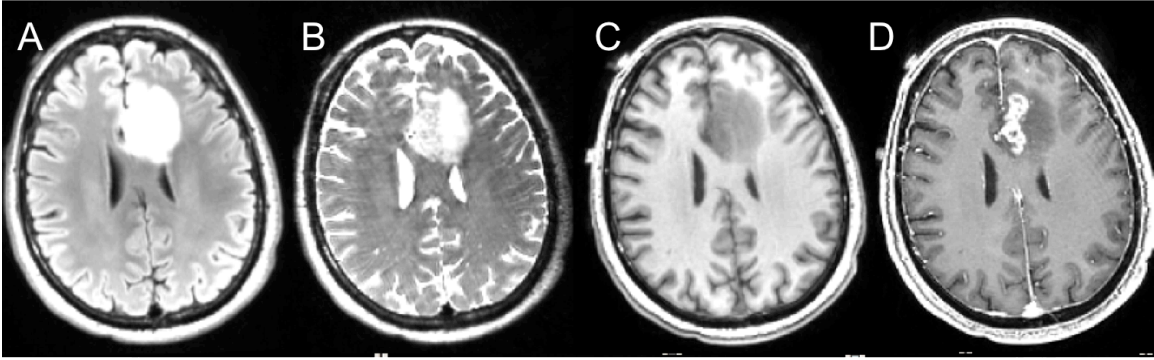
T2-weighted FLAIR (A) and FSE (B), T1-weighted pre-contrast (C), and T1-weighted postcontrast (D) MR images at 3 Tesla of a patient with newly diagnosed GBM.
